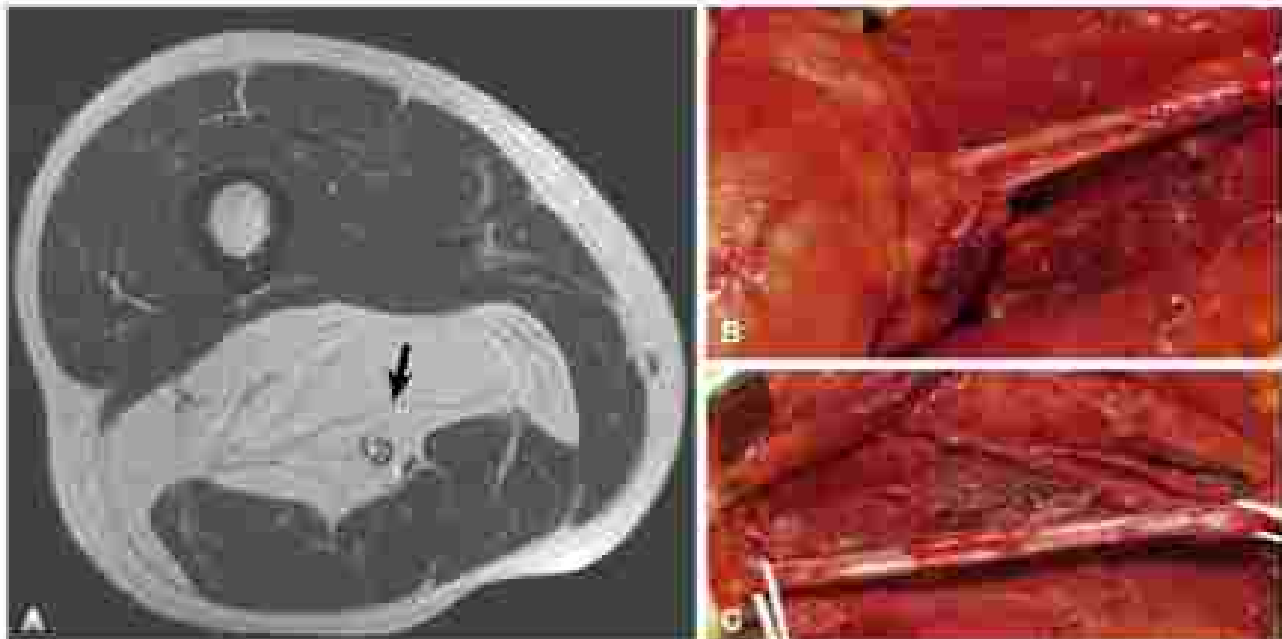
(A) Axial magnetic resonance image of the thigh shows a well-differentiated liposarcoma encasing the sciatic nerve (arrow). (B) Tumor peeled off the sciatic nerve. (C) Surgical field after resection of the tumor with dissection of the nerve.
